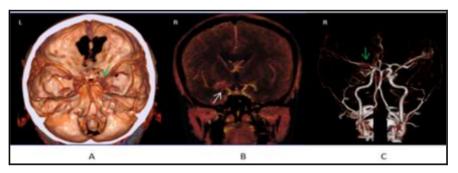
Head CT Angiography. Volume-rendered MDCTA image (A axial view and C coronal vier), B. Multiplanar reformation or reconstruction (MPR), clearly demonstrates stenosis in the right distal internal carotid artery (green arrow) with collateral lenticulostriate artery (white arrow), and right middle cerebral artery got supply from the posterior cerebral artery branches. Extracranial blood vessels are normal.
